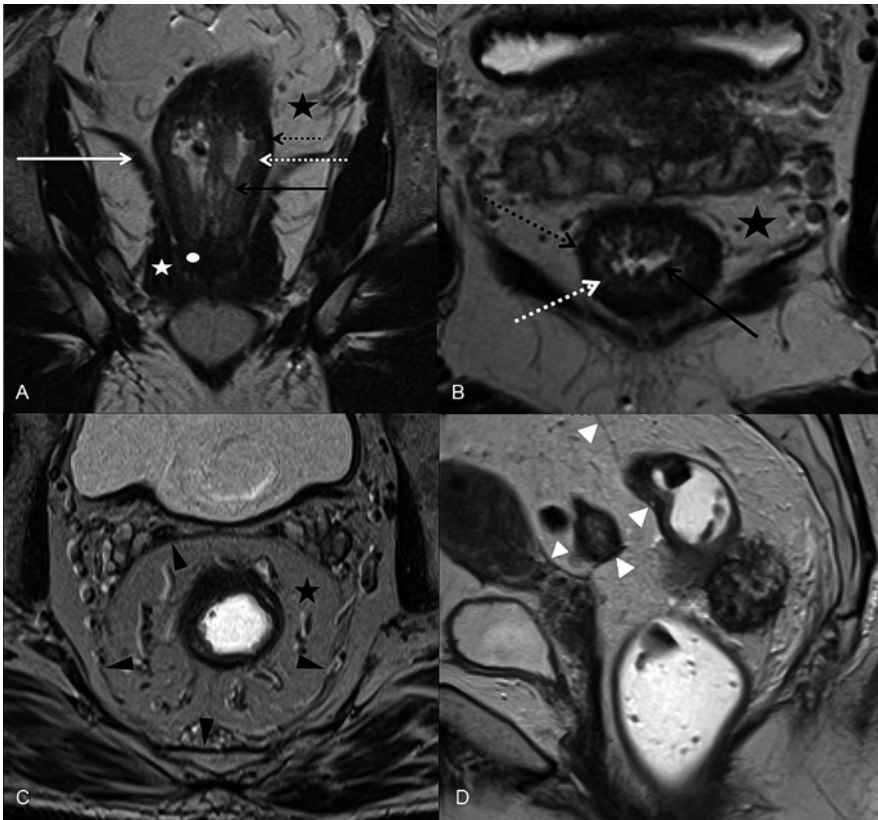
Normal rectal anatomy on T2-weighted MR images. Coronal (a) and axial (b) images through the lower rectum, axial image through the mid-rectum (c) and sagittal near-midline image (d) including the upper rectum. The sphincter complex is seen in (a) including the levator ani (white arrow) which is contiguous with the external anal sphincter (white star) that surrounds the internal anal sphincter (white circle). The layers of the rectal wall are seen in coronal (a) and axial (b) including the outer T2 hyperintense mesorectal fat (black star), T2 hypointense muscularis propria (dashed black arrow), T2 intermediate to hyperintense submucosa (dashed white arrow), and thin T2 hypointense mucosa (black arrow). The mesorectal fascia (black arrow heads) is shown in the mid-rectum (c). The thin hypointense band representing the peritoneal reflection (white arrowheads) is seen on the sagittal image (d)
